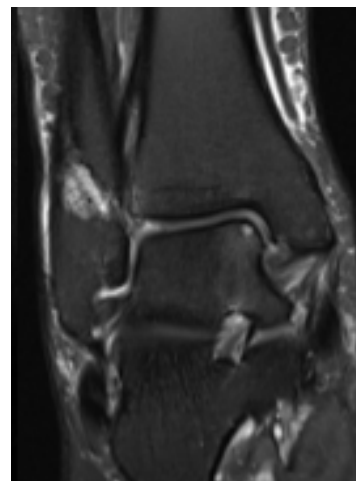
MRI delayed healing of the lateral malleolus fracture
